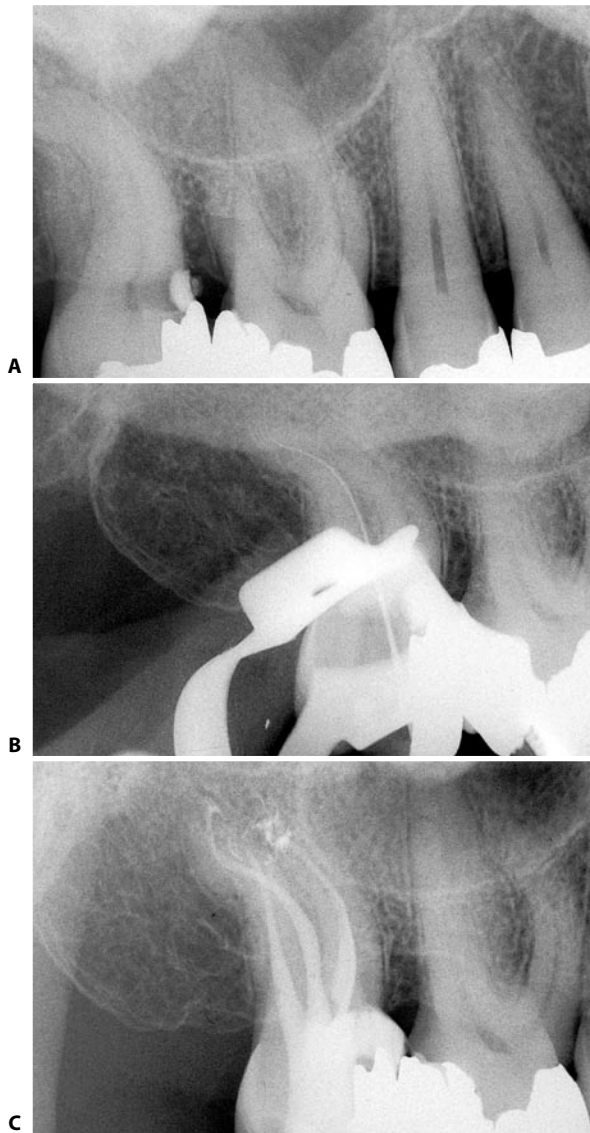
An upper right second molar with a double bayonet curve in the palatal root. A. Preoperative radiograph. B. Intraoperative radiograph. C. Postoperative radiograph.
